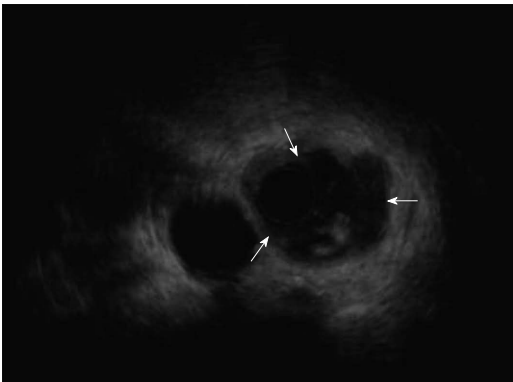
Endoscopic ultrasonography showed thickening about the semi-perimeter of the gastric fundal mucosa and a heterogeneous hypoechoic mass, the whole layer of the local wall involved (arrows).
